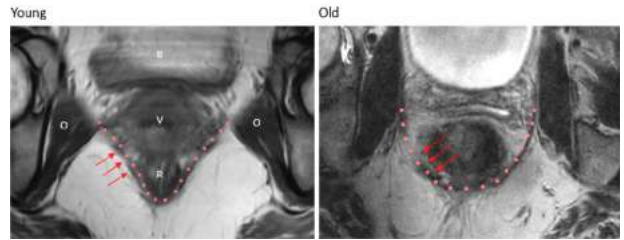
Tipped axial MR images of the iliococcygeal muscle (red fiducials) shape difference between young (convex) and old (concave) nulliparous woman without prolapse. Labeled are the bladder (B), vagina (V), rectum (R), and obturator internus (O).
